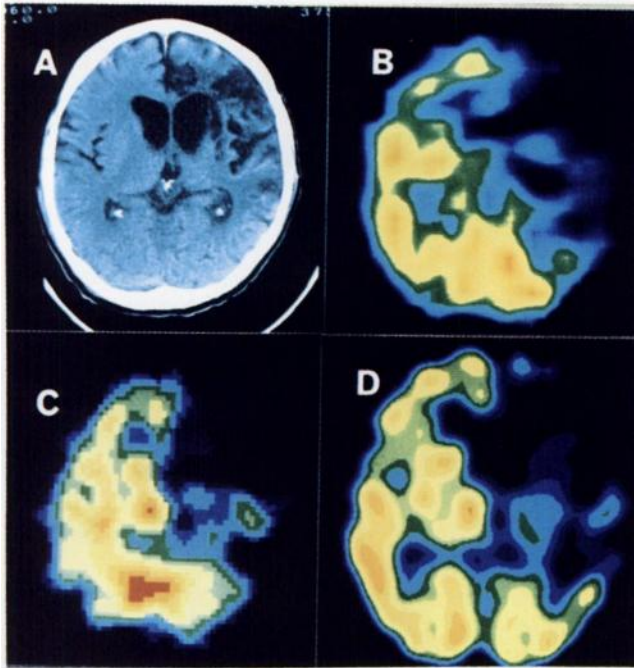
Three SPECT images obtained 55 mm above the OM line in a patient with right internal carotid artery occlusion and massive low density areas on brain CT (Subject 8). (A) Brain CT. (B) rCBF images obtained with ^{133}Xe . (C) The functional map obtained by our method. (D) The conventional [^{123}I]IMP image.
